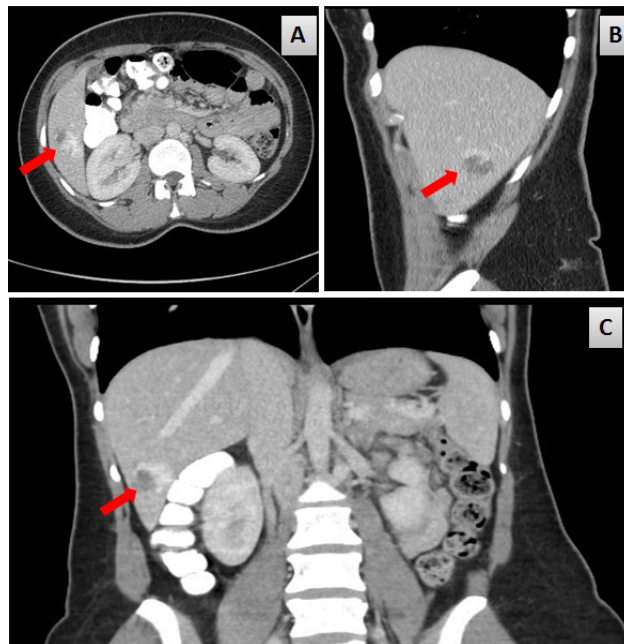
Contrast enhance CT Scan depicting hepatic haemangioma (shown with red arrow) in (A) Transverse plane (B) Sagittal plane (C) Coronal plane .
